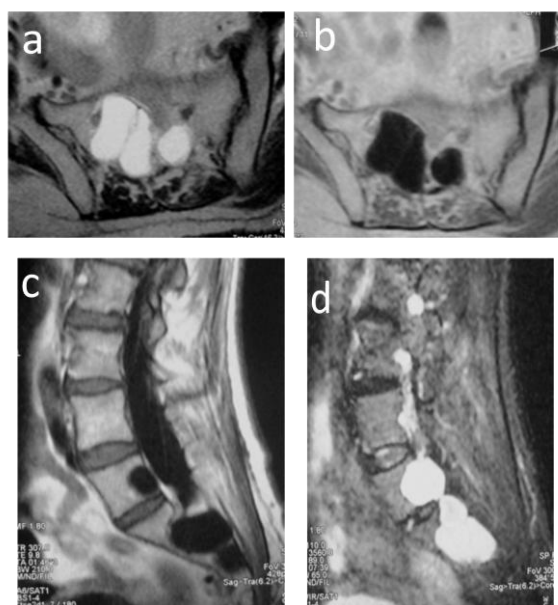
(a, b, c & d): MRI of the lumbosacral spine (in axial plane – figures 1a & b and in sagittal plane – figures 1c & d) revealed multiple, well circumscribed, fluid-filled cystic lesions arising from L5 to S4 vertebral levels, largest one measuring 3.5x2.5 cm with widening of spinal canal, widening of neural foramina and scalloping of adjacent vertebral bodies. The lesions were hypointense on T1W and hyperintense on T2W & STIR images.
